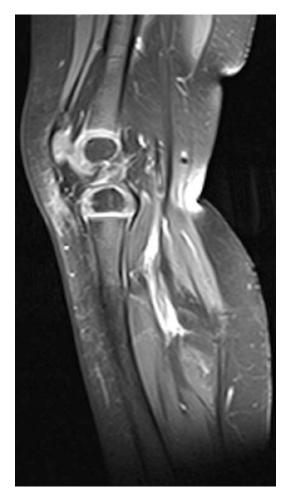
MRI Sagittal STIR sequence 16 months after commencement of chemotherapy showing almost complete response to systemic therapy alone
